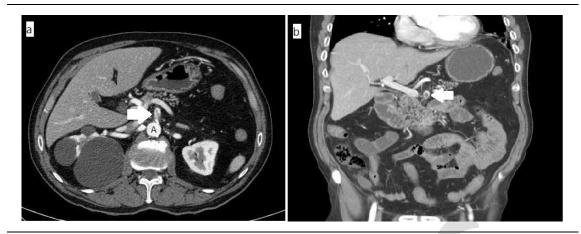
Abdominal CT scan with IV contrast. Axial (a) and coronal (b) section, white arrow revealed the complete thrombosis of SMA with the calcification at its origin. (A; aorta), SMA; superior mesenteric artery
